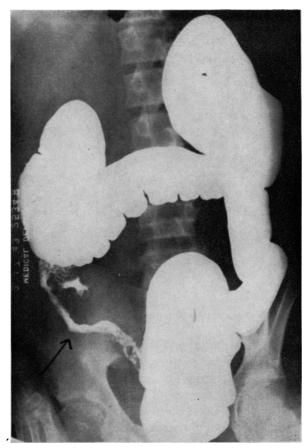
Roentgenogram showing narrowing of lumen of ileum. Note amount of barium in large bowel before opaque media could be forced into the ileum.
